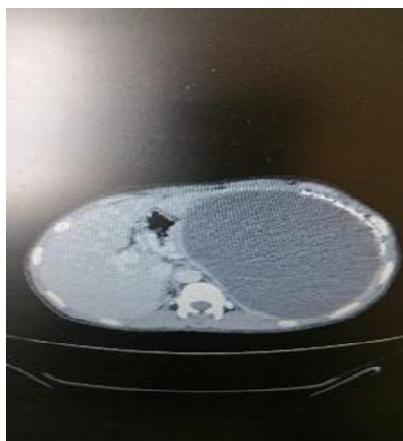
CT scan of the abdomen demonstrating splenic hydatid cyst
